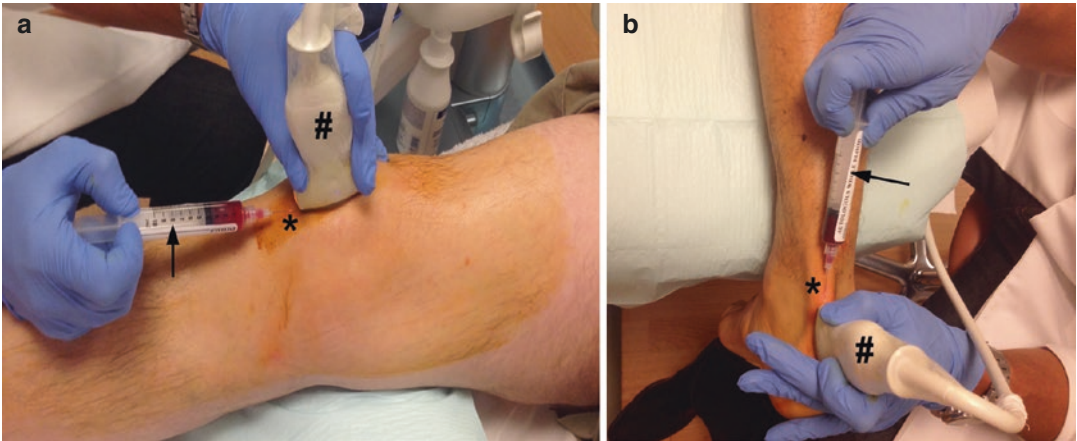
Ultrasound-guided application of PRP (*arrow*) in a patellar (a) and in an Achilles tendon (b). Using a US-guided (#) technique allows for a more accurate placement of the PRP into the tendons (*)
